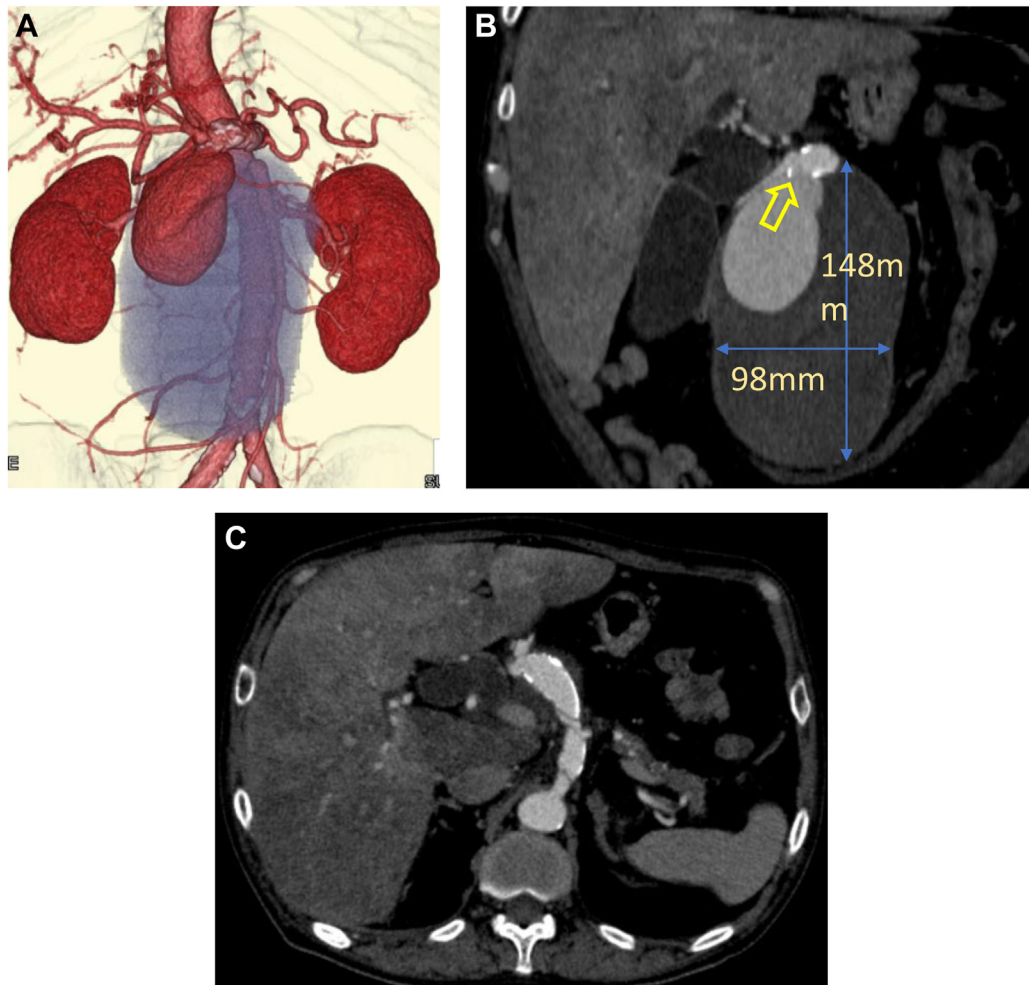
Preoperative computed tomography (CT) angiography (CTA). A, Three-dimensional reconstructed CT image: Preoperative CTA images showed dissection from the celiac artery (CA) to the common hepatic artery (CHA), as well as a large pseudoaneurysm downward from the distal end of the false cavity. B, Sagittal view of the pseudoaneurysm measuring 98 × 148 mm. The *arrow* denotes the orifice of the pseudoaneurysm. C, Dissection from the CA to the CHA.
